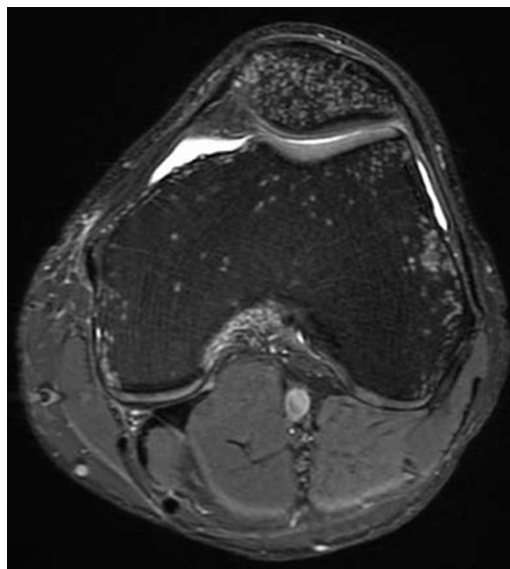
Patellar hyperemia after immobilization in an adult man. Axial PD-weighted fat-suppressed MR image of the left knee shows multiple punctate foci of increased signal intensity throughout the patella, with similar but less prominent changes in the distal femur. (Courtesy of Robert Boutin, MD, University of California, Davis, Calif.)
